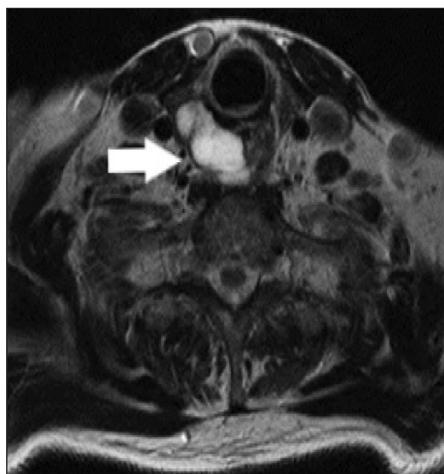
Axial T2 magnetic resonance imaging at the level of the cricoid demonstrates a T2 hyperintense mass arising from the cricoid cartilage (white arrow).
